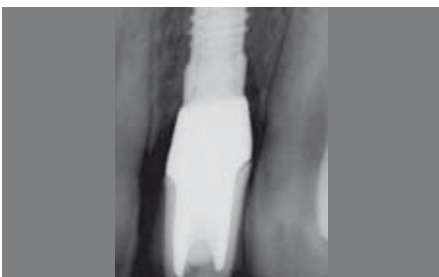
Radiographic control scan (dental film) after inserting the superstructure.
